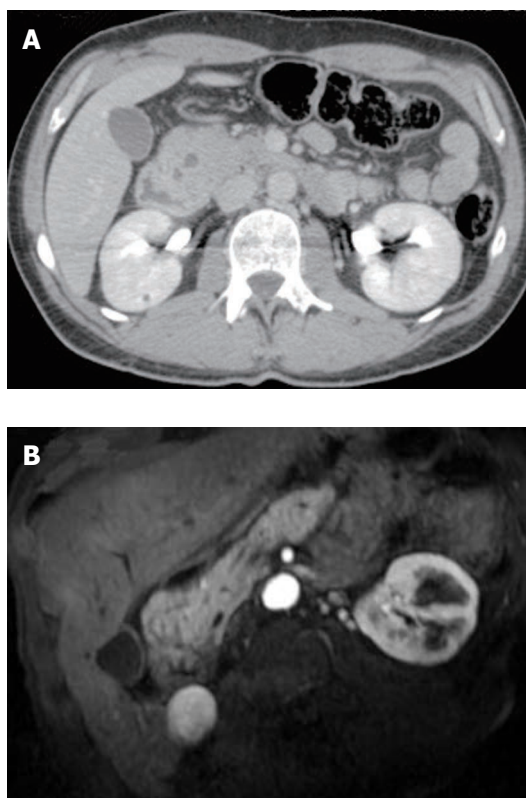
Case No. 2 computer tomography duodenal and pancreatic gland evaluation. A: Enlarged pancreatic head and the presence of multiple cysts between the enlarged pancreatic head and the duodenum (multidetector computer tomography); B: The remaining pancreas was normal as demonstrated by the magnetic resonance imaging.
